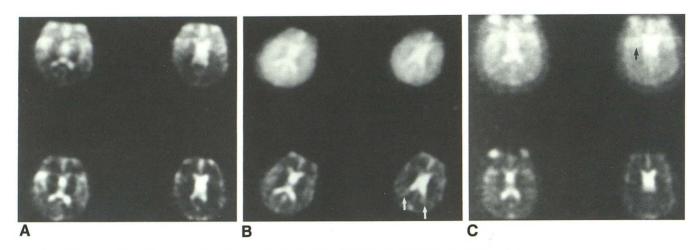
A, Normal sodium MR images. Upper two are FID images and bottom two are corresponding 18-msec images. B, Sodium study of patient 1 shows increased signal in periventricular white matter noted by small arrows (see Fig. 4). C, Sodium study of patient 4 shows increased signal in deep matter denoted by small arrow best seen on FID image (see Fig. 5).
